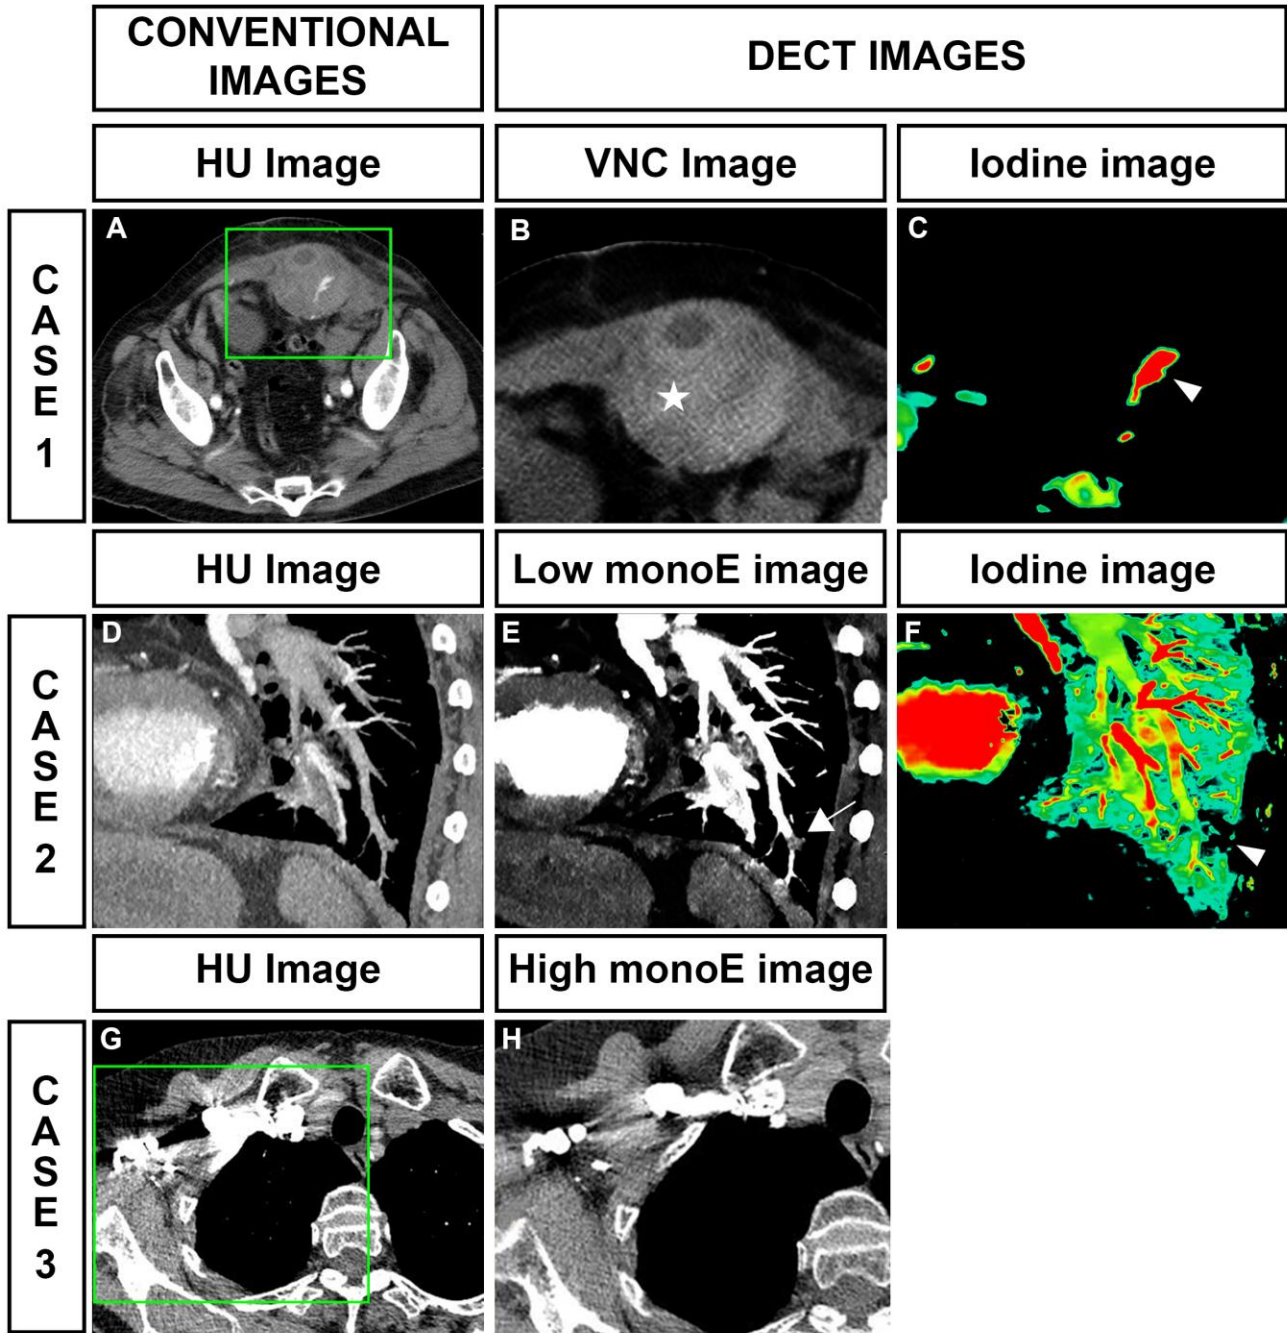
Examples of dual energy CT images. Case 1: In the conventional image (A) iodine cannot be discriminated from blood, but can be in the Virtual non enhanced (VNC) (B) and iodine images (C) where blood is highlighted with a star and iodine suffusion with an arrowhead. Case 2: The conventional image (D) didn't allow the diagnosis of a distal pulmonary artery thrombus due to imperfect opacification of the blood. However, the iodine image (E) revealed a
